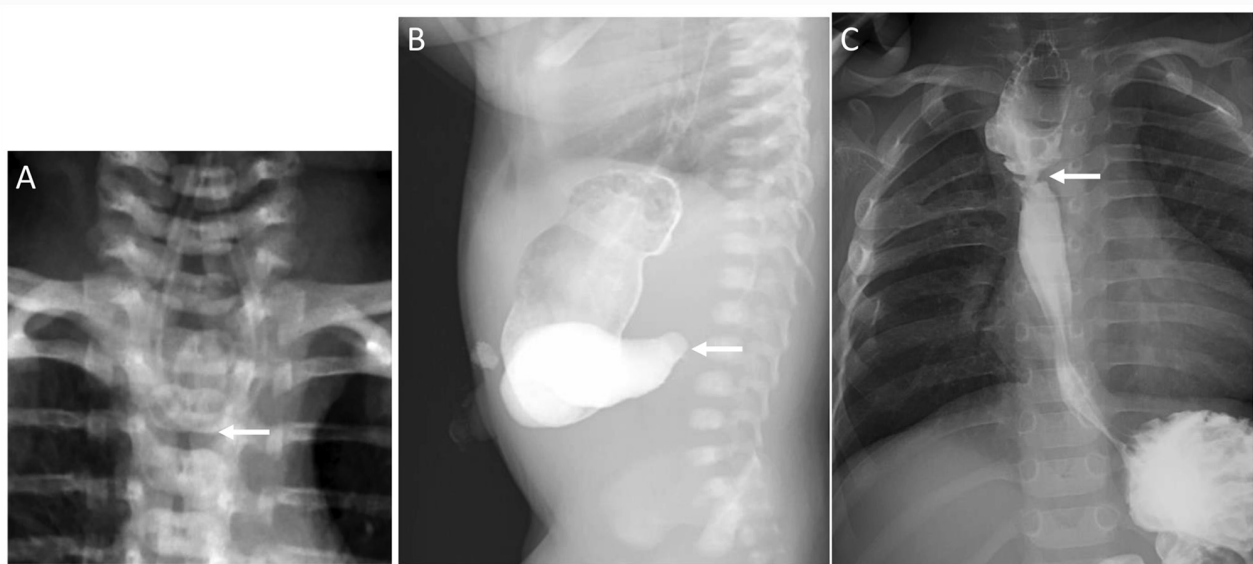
X-ray analysis of patient 1. (A) A positive X-ray confirmed coiling of the nasogastric tube in the upper esophageal pouch (arrow). (B) Upper gastrography confirmed the patency of esophageal anastomosis after the first stage operation and demonstrated a large dilated stomach with duodenal obstruction (arrow). (C) Recurrent anastomotic stricture in the esophagus with <3-mm inner diameter was observed by esophageal radiography at 12 months during the follow-up period (arrow).
